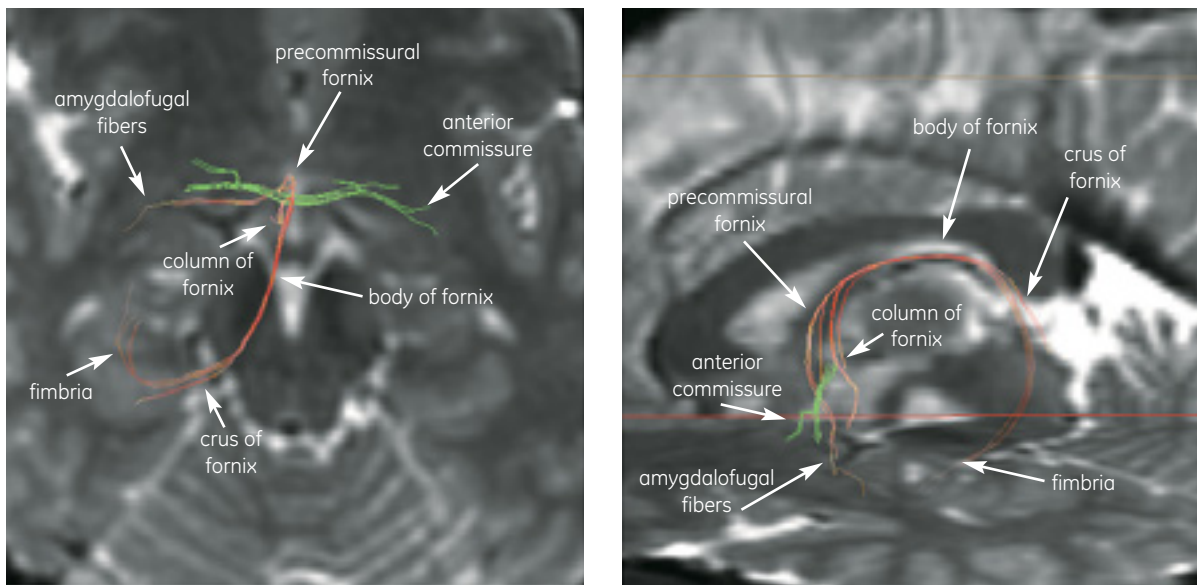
Multimodal volume neuroimaging combining 3D-FSPGR, Cube™ (T2WI and FLAIR), and volume DTI can bring about a paradigm shift from a 2D to a 3D approach in clinical neuro-magnetic resonance imaging.
